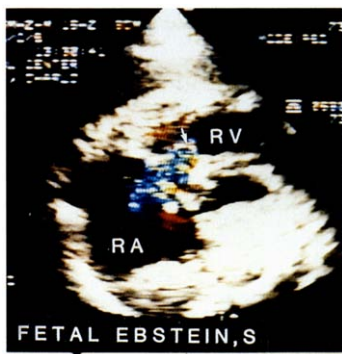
Case 20. Doppler flow echocardiogram obtained in a 32 week old fetus with Ebstein's anomaly of the tricuspid valve. The tricuspid septal leaflet is inferiorly displaced along the interventricular septum, with the tricuspid regurgitant jet (arrow) originating at a level midway into the right ventricle (RV). Abbreviations as in Figure 1.
